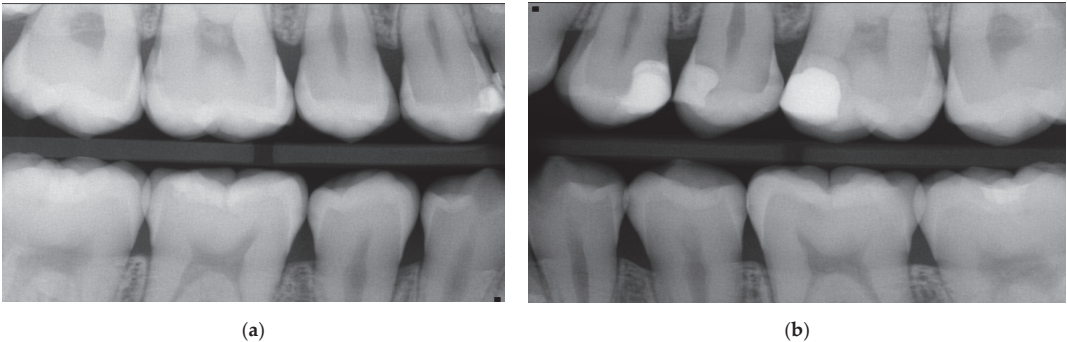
Bitewings on the right (a) and left side (b) 16 months after SF application show the stages of proximal lesions as well as the integrity of the restorative procedures (06/2023, age: 17 years old) indicating a clear reduction in caries activity and stability of the lesions. For a lesions assessment, see Table 1.
